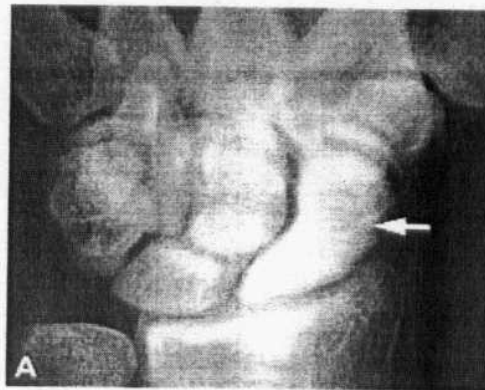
An anteroposterior radiograph shows diffuse sclerosis of the scaphoid. The deformity of the proximal aspect of the proximal pole is known as the “nipple sign” and is sometimes seen in association with scaphoid fractures. There is relatively little sclerosis of the distal pole (arrow) when compared with that present in the proximal pole(Quoted from Stoller and Brody, 1997).
